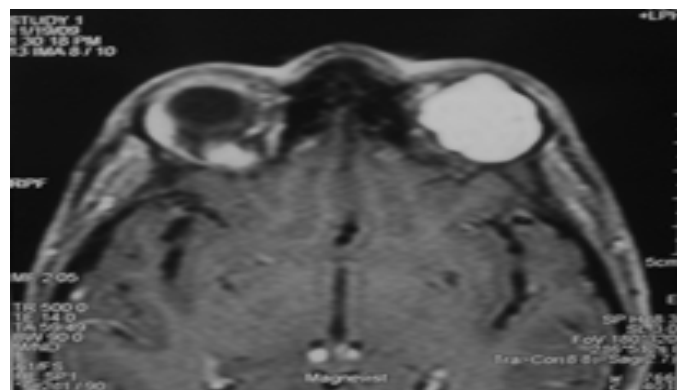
MRI: Contast enhanced image showing hypointense orbital mass
